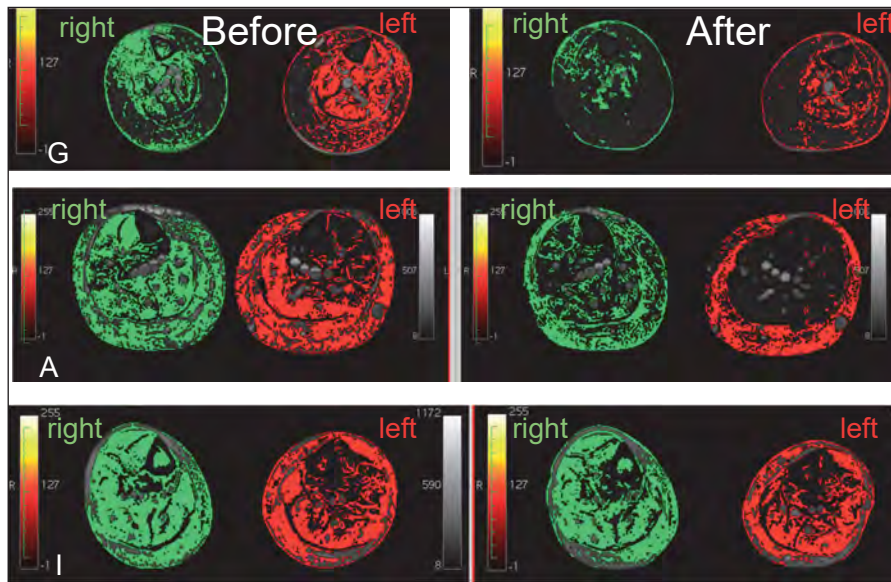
T2-weighted MRI image of the lower legs of patients A, G and I before and after treatment of both legs. Water content on the right coloured green, left red. The water content is reduced after treatment.
